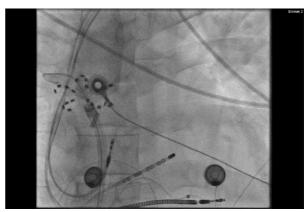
Right anterior oblique x-ray projection of 15° of Farawave catheter (flower configuration) in right pulmonary veins in patient with implanted ICD.
